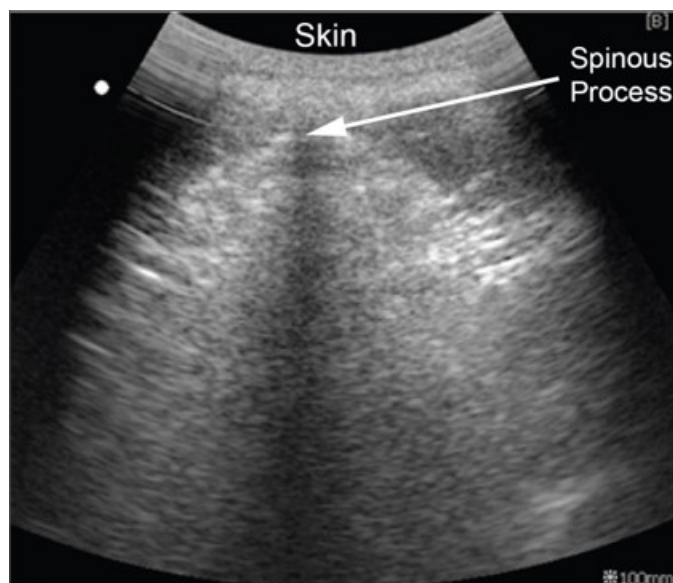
Ultrasound Image Feature of Bone Region in the Transverse View.
